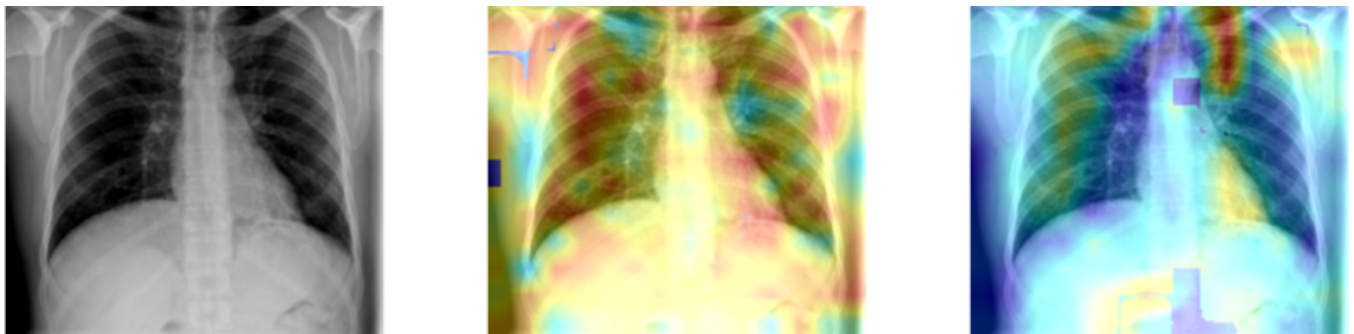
Visualization of Attention Maps. The left figure is the original Normal chest X-ray, and the middle figure and right figure are the attention maps of the final attention layer ResNetAtt and ResNetAttRadi, respectively.
